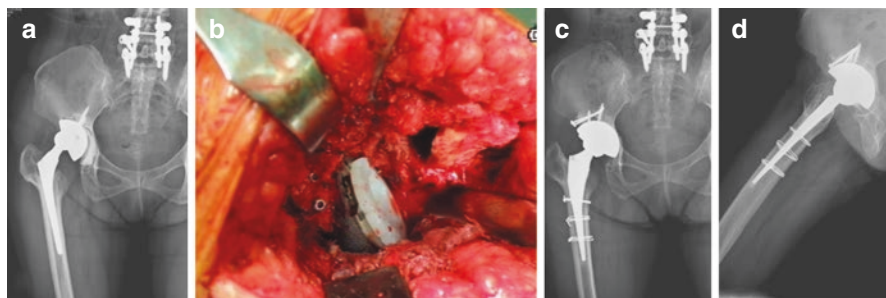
A 43-year-old woman with failed revision, right THA performed 15 years previously. Preoperative radiographs and intraoperative findings showing a Paprosky type IIIA acetabular defect involving superior and posterior wall (a and b). One and a half year after bulk and morselized allografts reconstruction of the acetabular defect and noncemented TM cup revision showing well-fixed cup and graft healing in radiographs of the pelvis and hip (c and d) (these pictures were agreed by the patient for publication)
